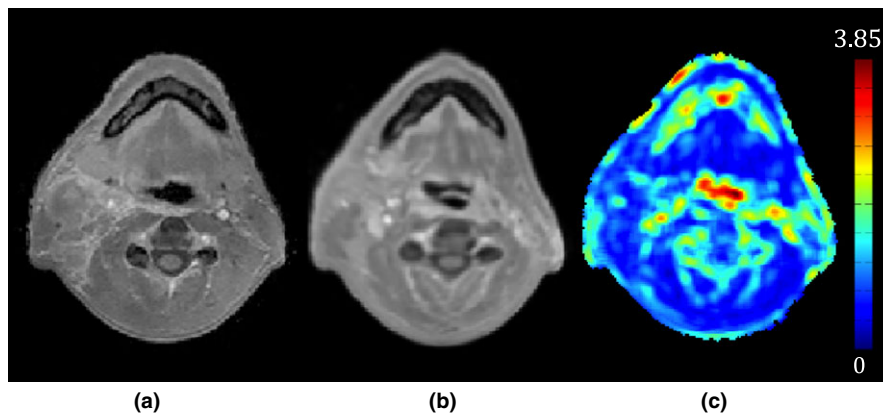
Example of a generalized registration error (GRE) map that is used as a measure of local similarity between the two registered MRIs. (a) A new patient's MRI, (b) an MRI in the atlas co-registered with (a), and (c) the GRE map between (a) and (b). As seen in (c), most of the registration errors arise near the air-tissue interfaces.
